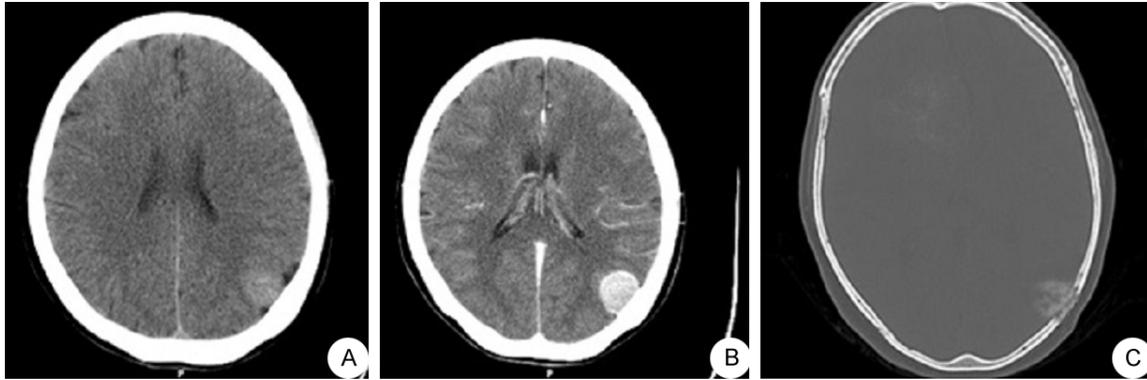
CT scans of tumors in patients. A male patient aged 63 years old with left occipital meningioma. A: There is slightly higher-density shadow in a quasi-circular shape in the left occiput, and the broad base attaches the inner plate of cranial bone. B: The tumor is obviously enhanced after enhancement, and dural tail signs can be seen. C: The bone window indicates the significant destruction of parietal bone.
